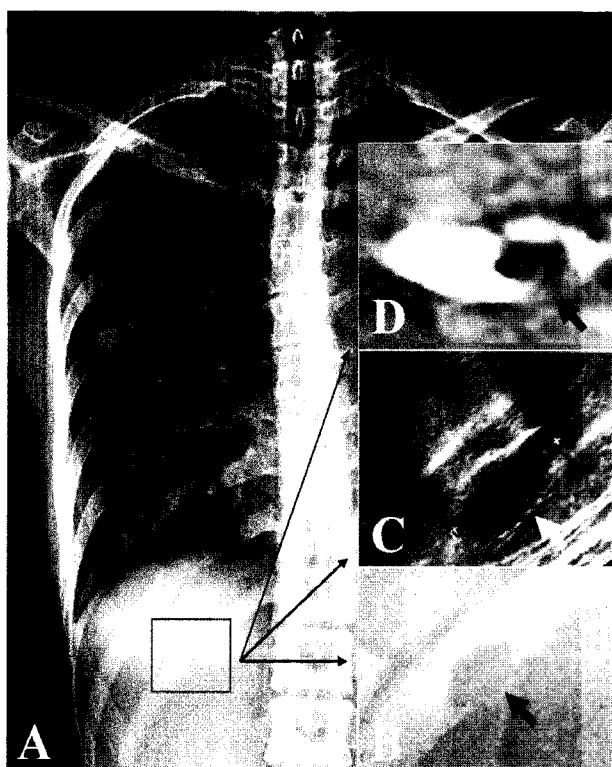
(A) Bone technique supine radiograph of the chest shows a small transversely coaxial lytic lesion in the middle portion of the right 11th rib arc (framed). (B) Magnified radiograph reveals inferiorly eccentric lysis with sclerotic superior border and ballooned inferior border. Thin lower cortex is barely discernible (arrow). (C) Sonograph shows lesional content to be hypoechoic with thick superior and thin inferior hyperechoic border. Note marked thinning of the inferior cortex (arrow). (D) CT shows low density lesional content with thickened superior border and thinned inferior border (arrow).
